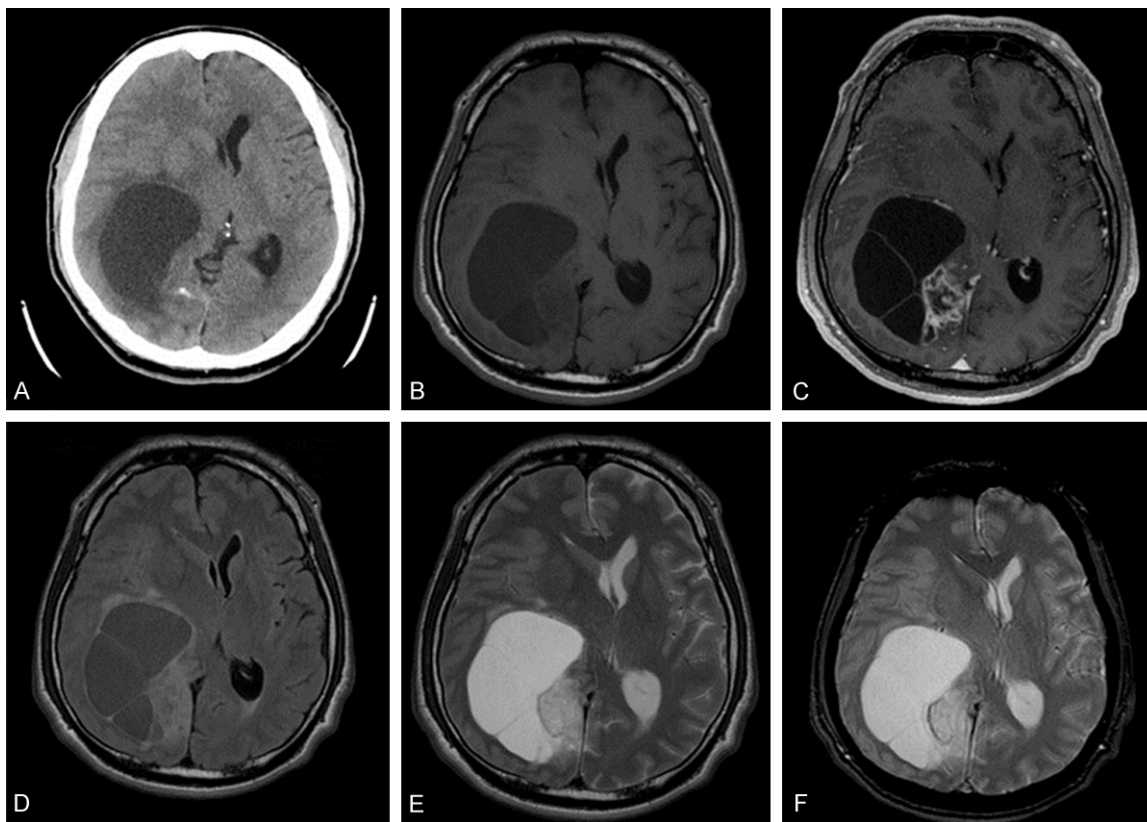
Preoperative head CT (A) and MRI (B-F). A large cystic tumor occupying the medial region of the right occipital lobe is seen. A heterogeneously enhanced, mural nodule-like, solid component is located on the medial wall of the unilocular cyst. (A: CT, B: T1-weighted image, C: T1-weighted image with contrast enhancement, D: Fluid-attenuated inversion recovery image, E: T2-weighted image, F: T2-star image).
